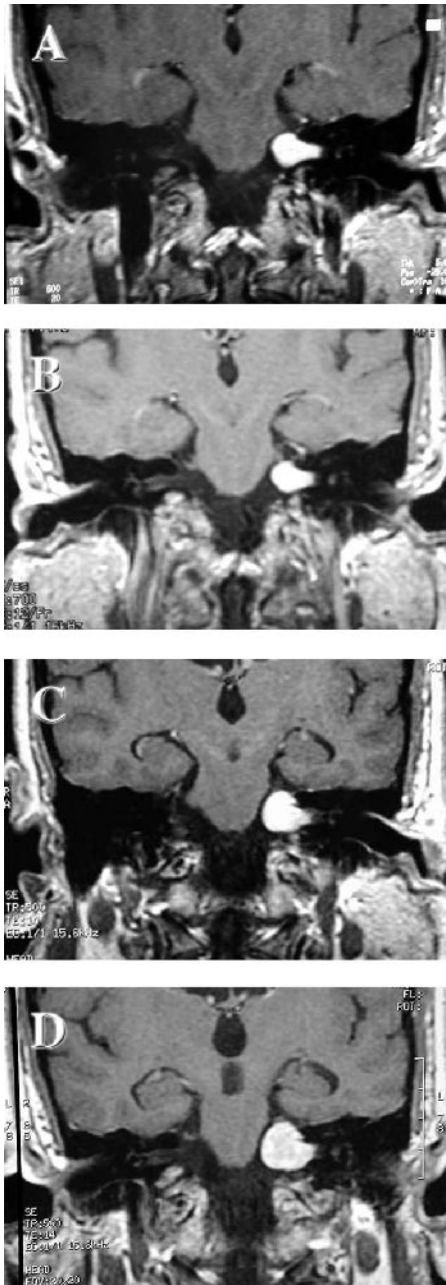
T1-weighted, post-gadolinium-enhanced coronal MRI scans of the cerebellopontine angle from Case 4. A 1.3-cm left-sided VS was diagnosed before gamma knife radiosurgery (A). Slight tumor involution was observed initially at 1 year after radiation (B). (C and D) Four to 5 mm of tumor regrowth at 2 years and 3.5 years after radiosurgery, respectively. Note the decreased attenuation within the core of the tumor (D).
